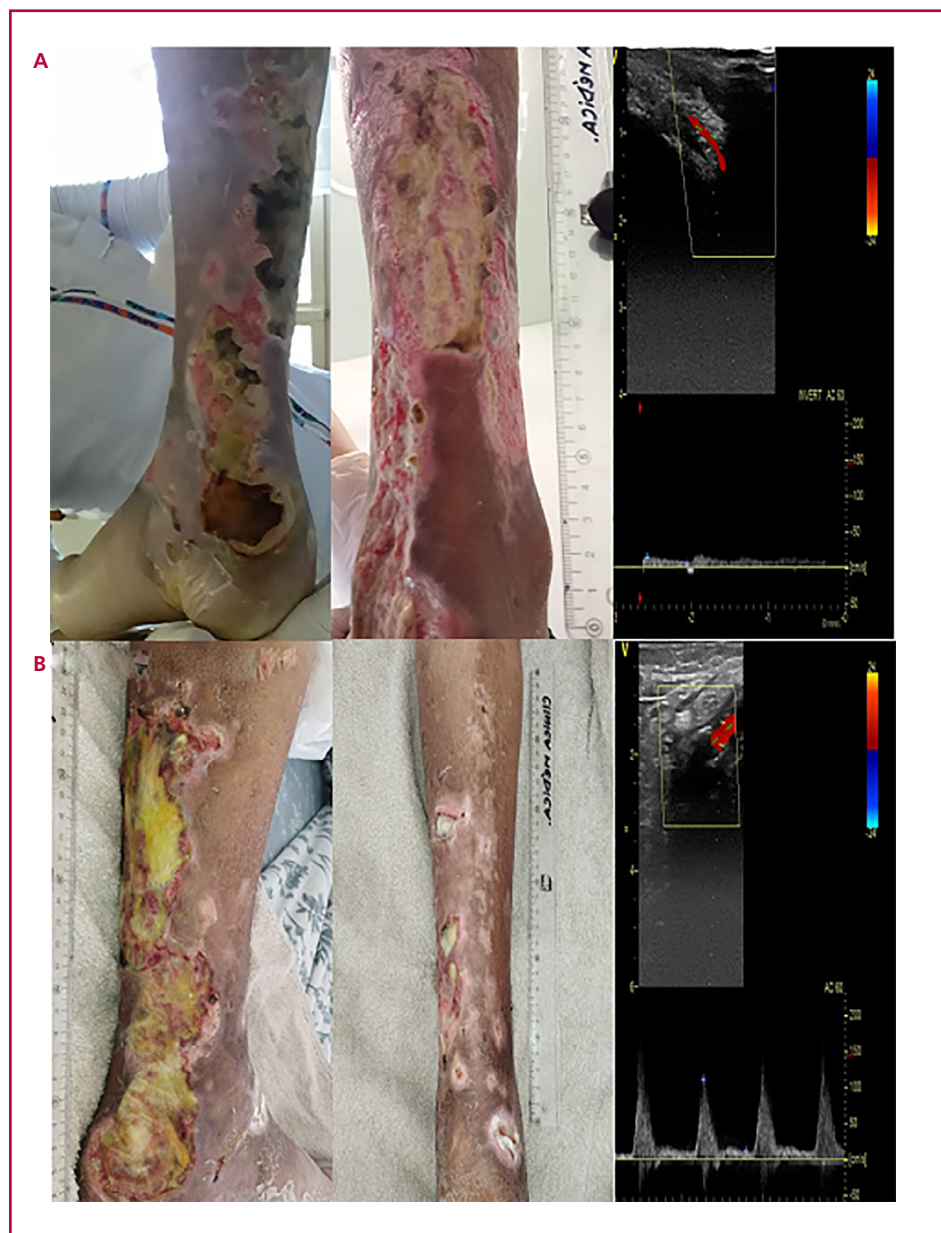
A. ADMISSION: from left to right: ulcerative lesion upon hospitalization, before and after surgical toilet. Right: Doppler ultrasound with monophasic flow of the anterior tibial artery.
